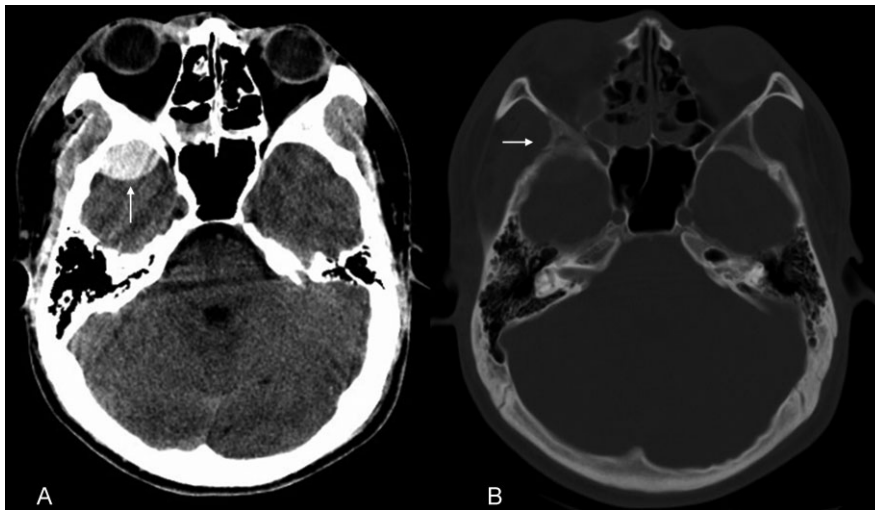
Venous epidural hematoma. (A) The axial computed tomography image shows a biconvex, homogeneous, high-attenuation extra-axial collection within the right middle cranial fossa (arrow). (B) The computed tomography image displayed in the bone window reveals a fracture of the right greater sphenoid wing (arrow). The location suggests that the hematoma is due to disruption of the sphenoparietal sinus.
